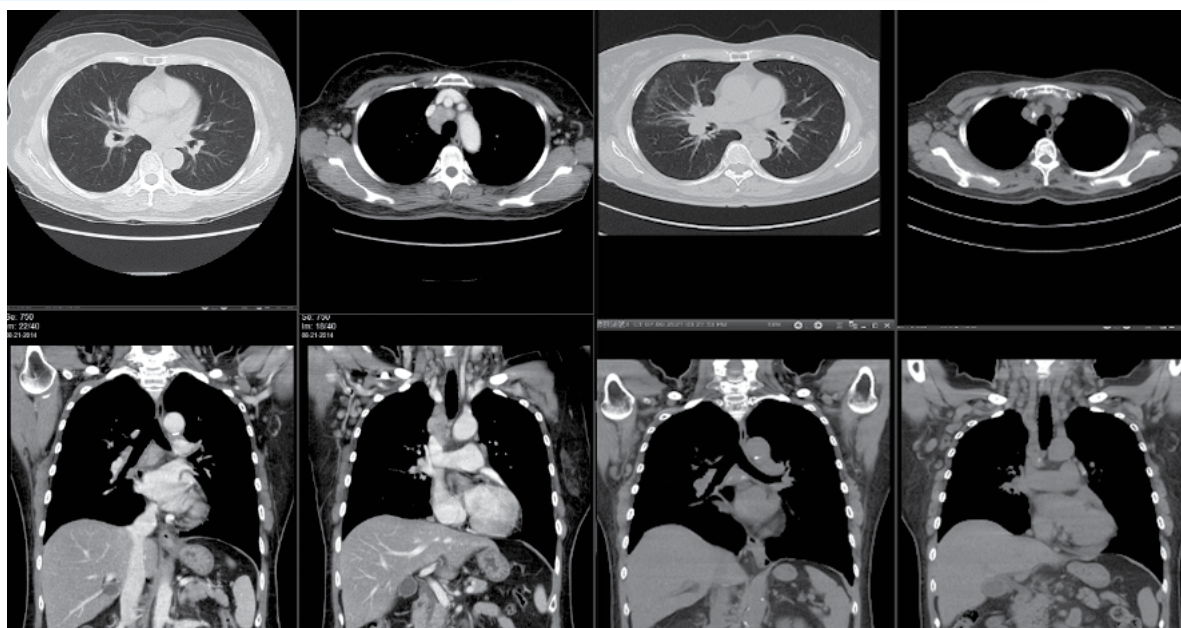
A- Chest CT scan axial and coronal views shows mediastinal lymphadenopathy. B- Follow up CT done 7 years later shows mild regression of lymphadenopathy with calcifications indicating chronicity.
